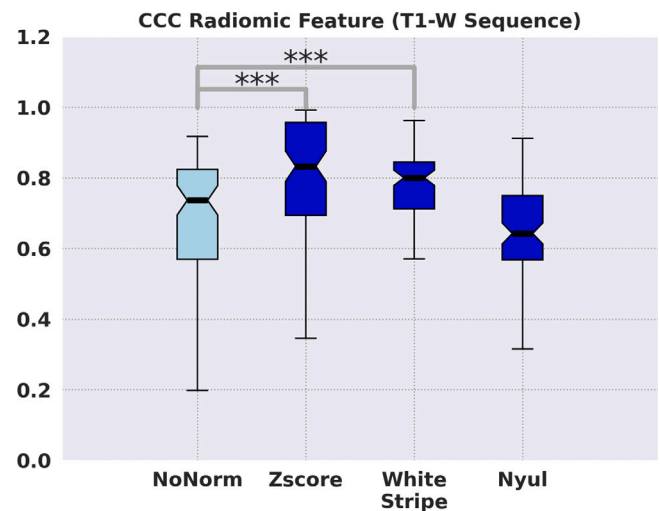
The distribution of CCC scores obtained from the radiomic features extracted from the non-normalized (NoNorm) T1-w MRI and the images normalized by the Z-score, WhiteStripe and Nyul methods. * (significant statistical difference).
